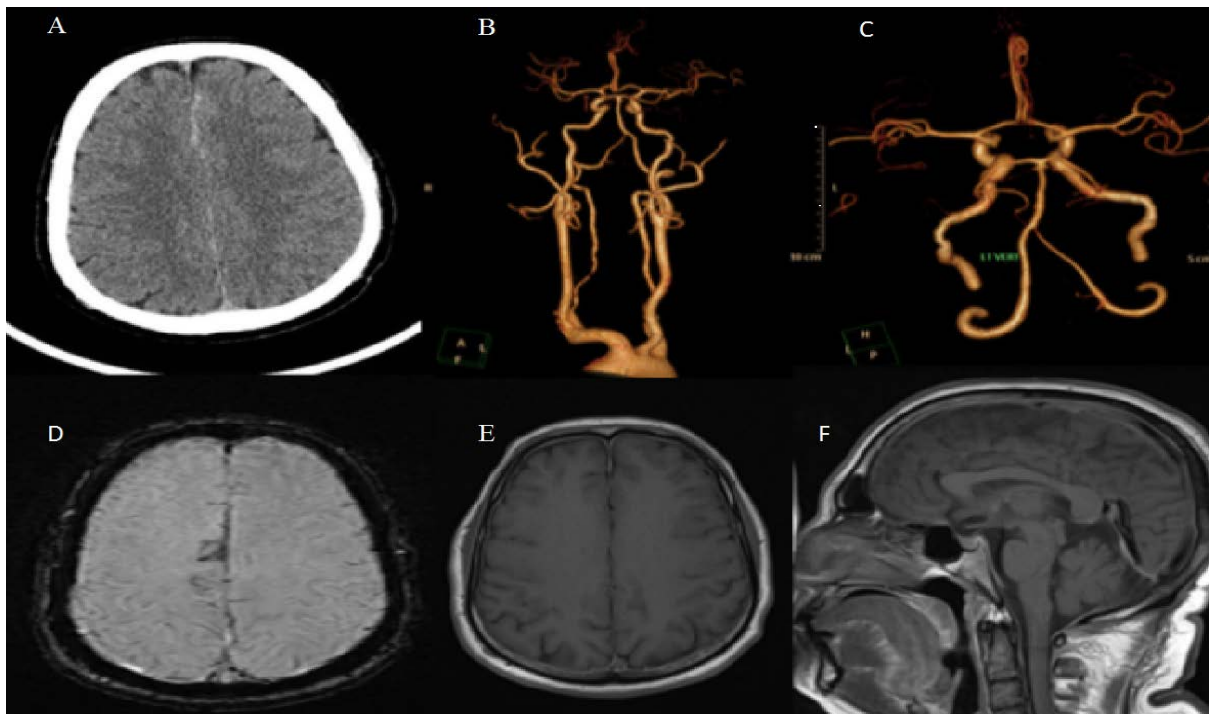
A - axial cut of initial CT showing interhemispheric SAH, B and C showing normal circle of Willis without any vascular pathology; D, E and F shows follow up MRI, D showing blooming in interhemispheric region on SWI sequence, E & F shows diffuse meningeal enhancement with corpus callosal buckling and sagging of brainstem, suggestive of Intracranial hypotension.
